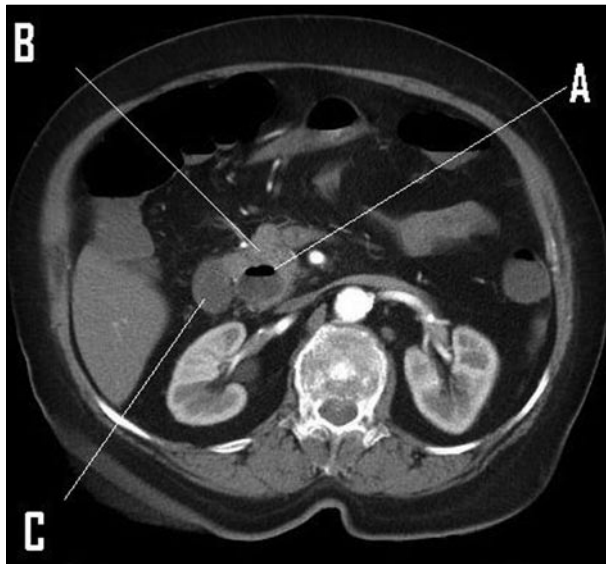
Initial CT scan of the abdomen shows
